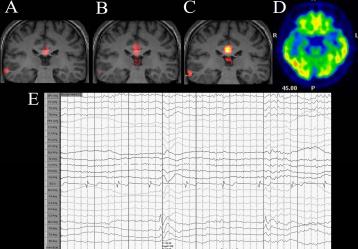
A 38-year-old man clinically diagnosed with epilepsy. A Coronal fALFF, B ALFF and C ReHo all reveal an abnormal activation on the right lateral temporal lobe. D  $^{18}\text{F-FDG}$  PET/CT image reveals low FDG uptake in the the right lateral temporal lobe region. E VEEG depiction of a right temporal lobe interictal epileptiform discharges at sphenoidal electrodes.
